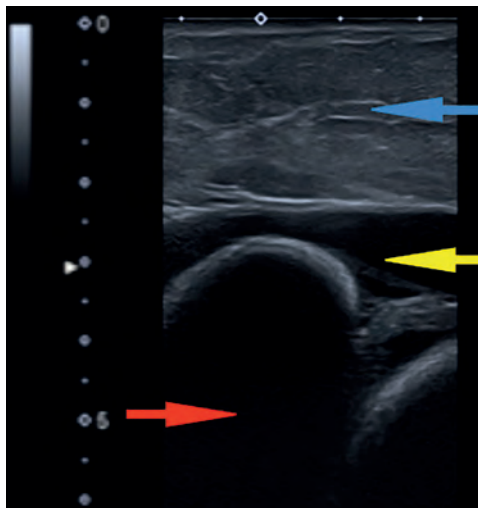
Ultrasonographic findings depicting seroma-associated BIA-ALCL of the left breast. Explantation of the left breast subsequently was performed. Note the seroma (red arrow) surrounding the periprosthetic space (yellow arrow). The implant is distinguishable by its folded surface. The blue arrow indicates the skin and subcutaneous layers.
